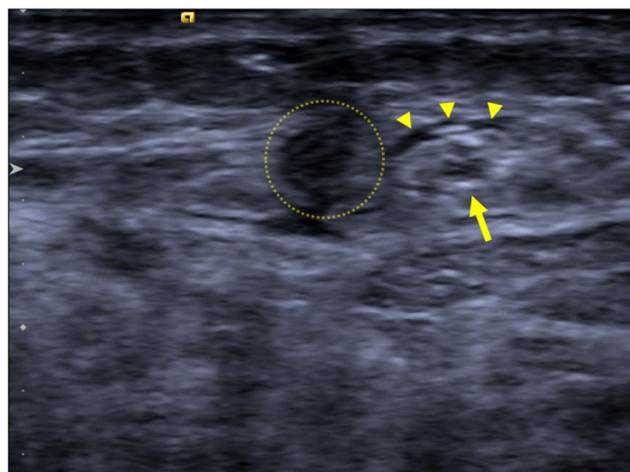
Transverse ultrasound image showing the small saphenous vein (circled) adjacent to the more oval-appearing sural nerve (arrow). There is fluid (arrowheads) surrounding the nerve from hydrodissection performed before the biopsy attempt
